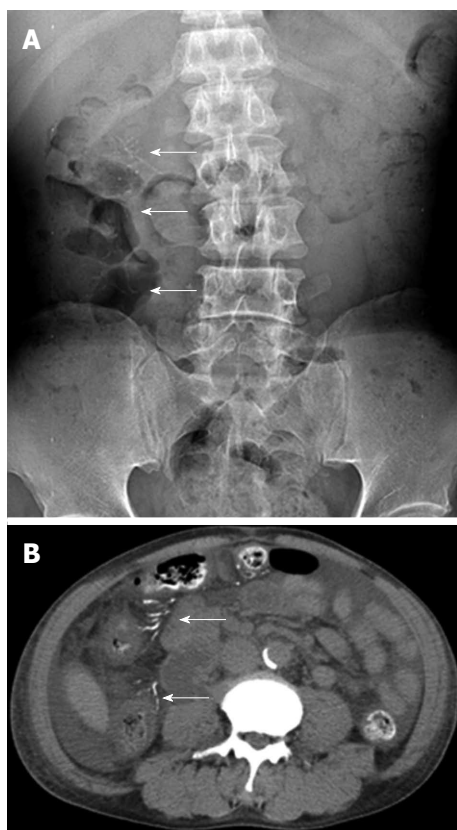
Kidney-ureter-bladder radiography and non-contrast enhanced computed tomography. A 56-year-old male suffered from right upper quadrant abdominal pain and fever. A: The kidney-ureter-bladder radiography showed threadlike calcifications (arrows) at right abdomen; B: The non-contrast enhanced computed tomography study revealed calcifications (arrows) at tributaries of mesenteric vein and wall thickening of the ascending colon. The diagnosis is phlebosclerotic colitis with active episode.
